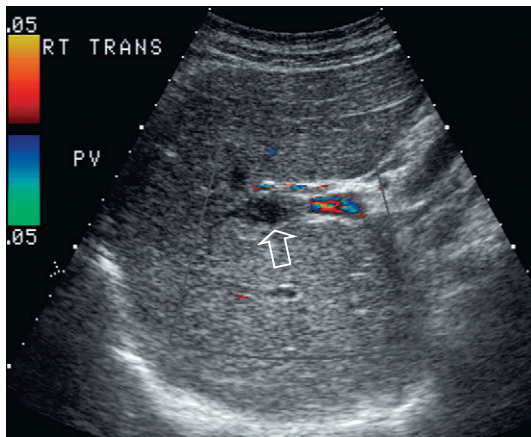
Oblique colour Doppler image of the porta hepatis. The pulse repetition frequency is appropriately set at a low level. Nevertheless, the trickle of flow is seen in the extrahepatic portal vein but within the liver itself no colour flow is identified. Indeed there are some low level echoes within the portal vein indicating fresh clot (arrow).
